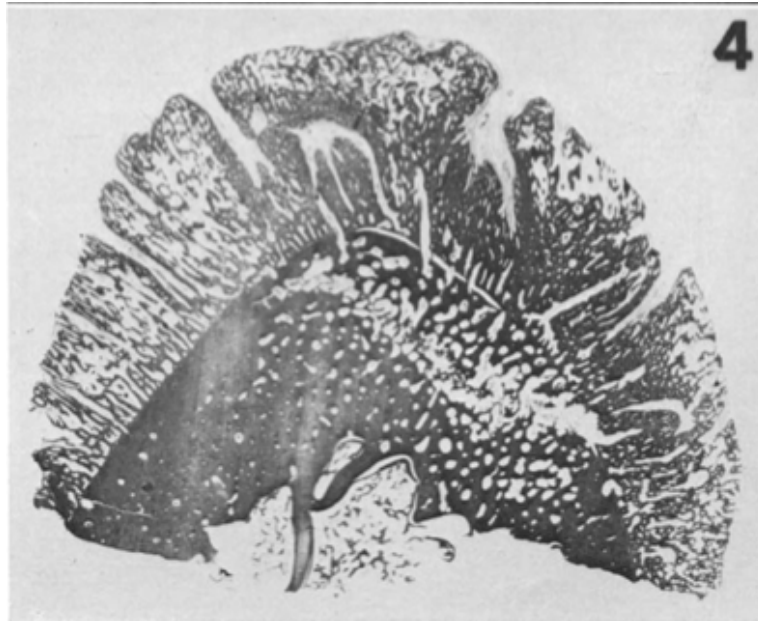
An x-ray taken from a cross sectional sample of a tibial cortex with multiple holes merging into a confluent lytic defect in the cortex.
